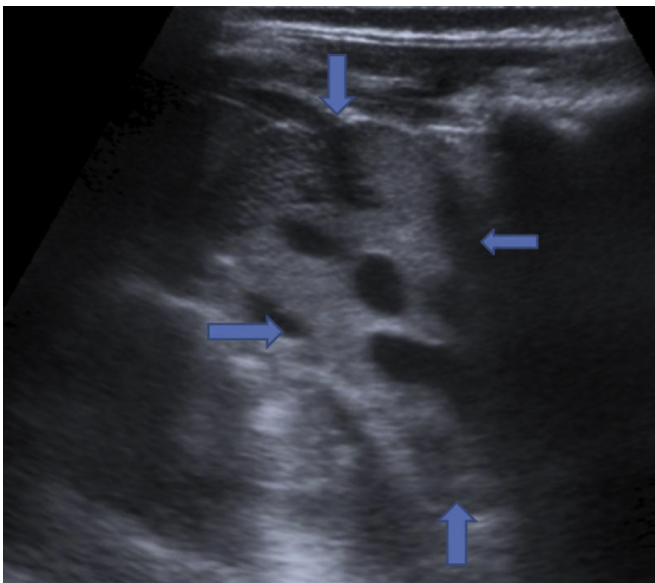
Longitudinal real-time ultrasound scan of the left side of the abdomen reveals solid echogenic mass with cystic areas (blue arrows).
